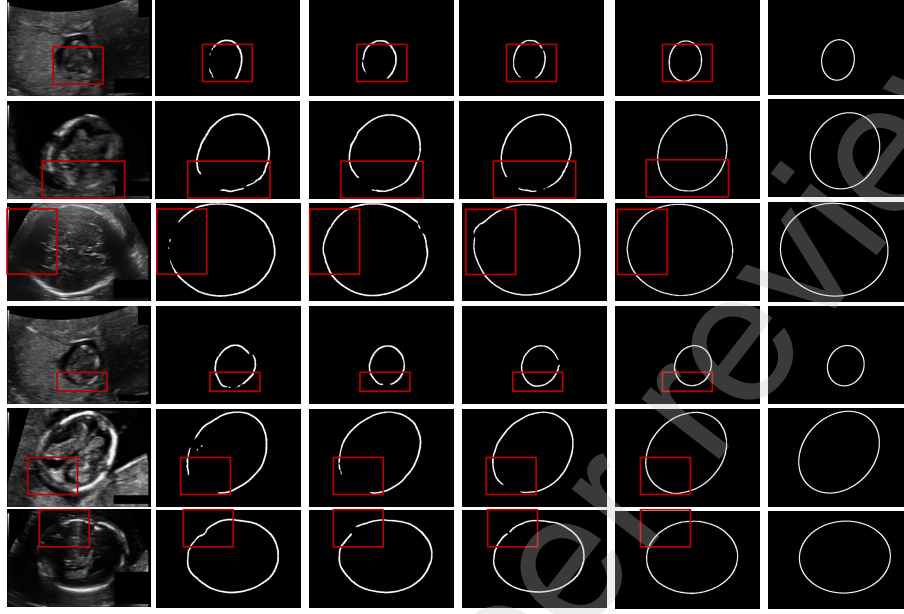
Qualitative evaluation of ablation study on the new test dataset. The first and the fourth row show examples with poor fetal head boundary contrast to the background. The images in the second and the fifth row are examples of fetal head boundary-blurring regions. The third and the sixth row presents examples with boundary missing regions. Each column shows the original ultrasound images (first column), the corresponding ellipse annotations (sixth column), the ellipse detection results obtained by Base (second column), Base+Seg (third column), Base+Seg+ESFF (fourth column), Base+Seg+ESFF+Shape (fifth column), respectively.
